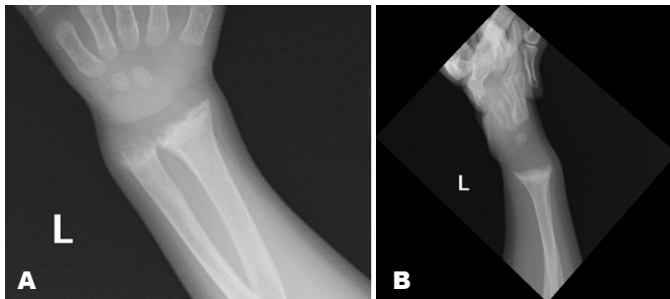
X-ray of left upper extremity. (A) Frontal view of left epiphyseal plate. (B) Lateral view of left epiphyseal plate and ulnar head.
